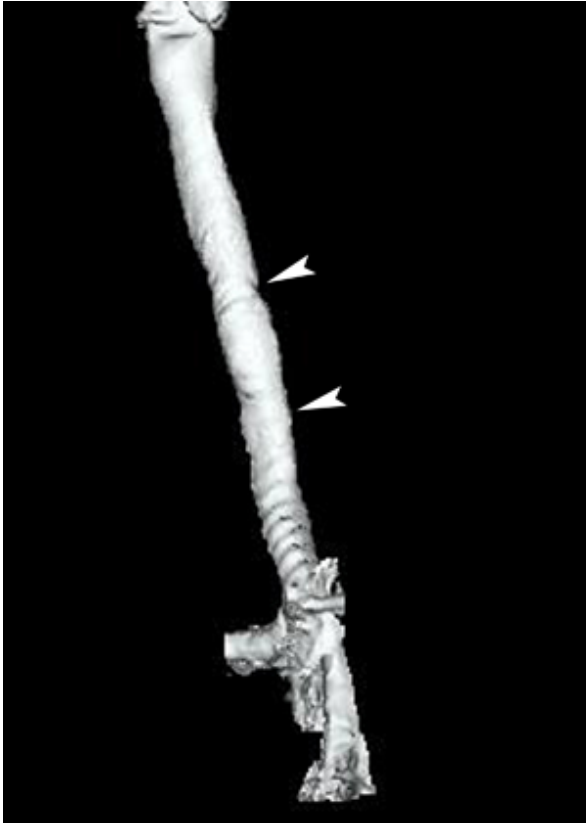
Lateral view of 3D reconstruction CT demonstrates disappeared deep laceration at the posterior tracheal wall (arrowheads).
